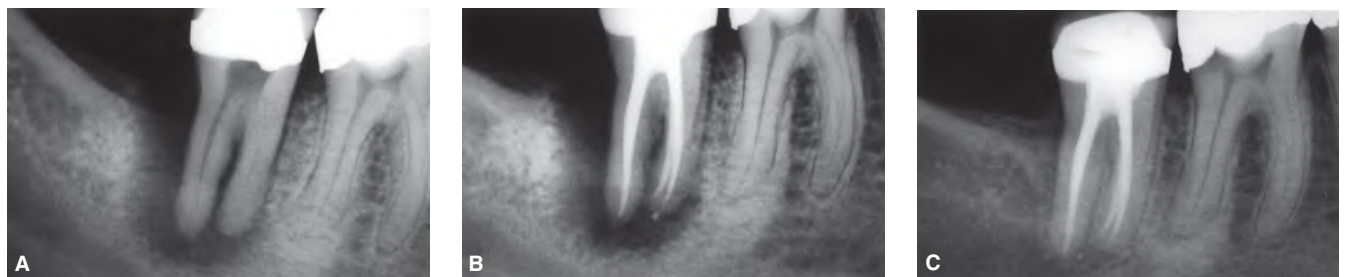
A. Preoperative radiograph of a second molar with pulp necrosis and evidence of severe asymptomatic apical periodontitis. B. Postoperative radiograph of the tooth. C. Postoperative radiograph two years after root canal treatment shows complete resolution of the periapical pathosis. (Courtesy of Dr. David Steiner, Gig Harbor, Washington, U.S.A.)
